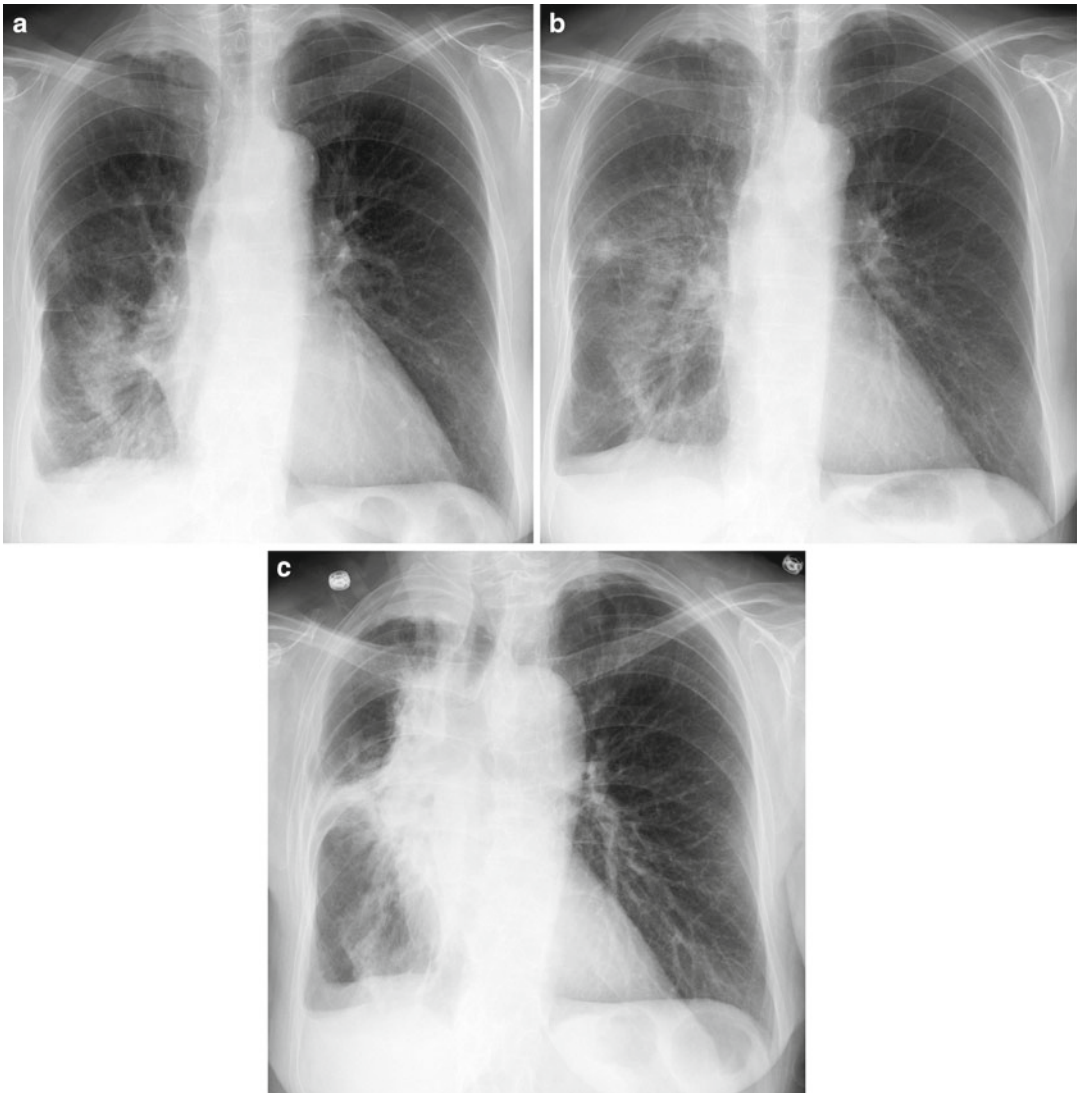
Progressive radiation fibrosis in a patient with lung carcinoma. (a–c) Sequential PA chest radiographs over a 1-year period show progressive radiation fibrosis in the right lung
